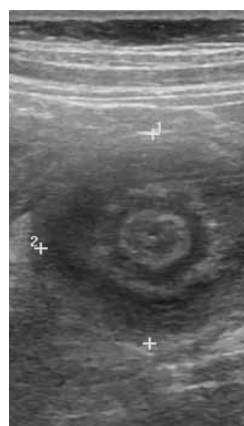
Target Sign in abdominal Ultrasound, showing abnormal cecum
